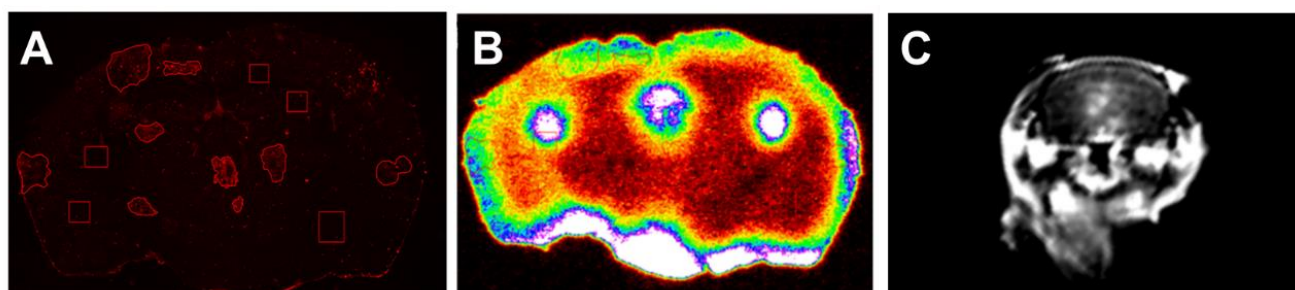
Differential tracer uptake in various imaging modalities. Accumulation of Texas Red 3K (A) and ¹⁴C-aminoisobutyric acid (B) in brain metastases of breast cancer using fluorescent and phosphorescent quantitative imaging. (C) T1 cortical Turbo Spin Echo MRI indicating gadavist enhancement in lesions within the brain.
